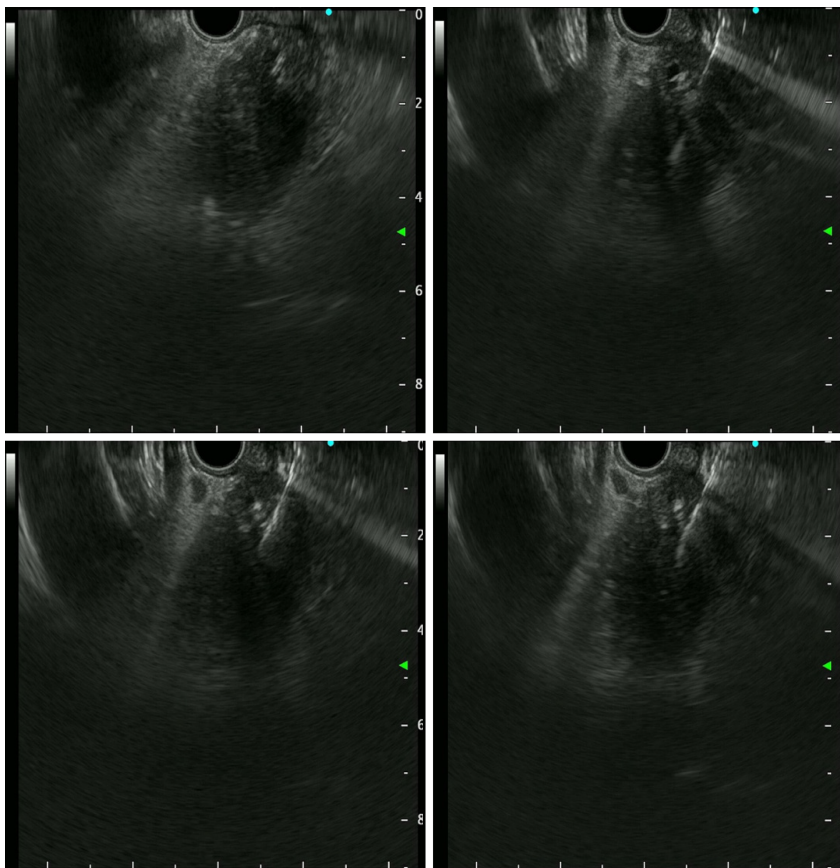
Endoscopic ultrasound-guided tissue sampling. Endoscopic ultrasound (EUS) showed a 36.0 mm × 32.9 mm sized ill-defined relative heterogeneous hypoechoic mass in the pancreatic head. EUS-guided tissue sampling (EUS-TS) was performed using a 22-gauge EZ Shot (EZ Shot 3 Plus; Olympus, Tokyo, Japan) using the fanning method.
